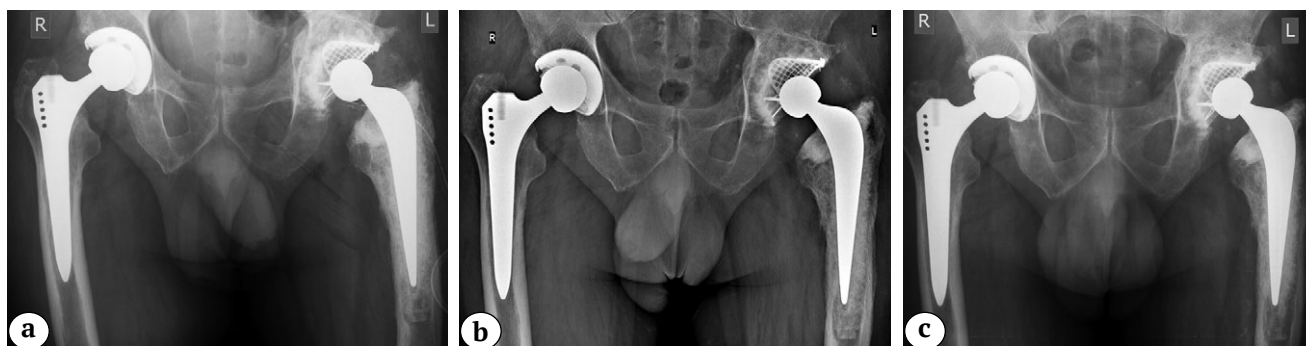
Plain pelvis X-rays after the left hip revision:
